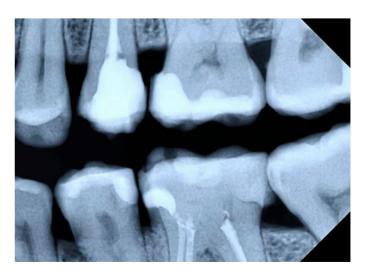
Bitewing radiography.
